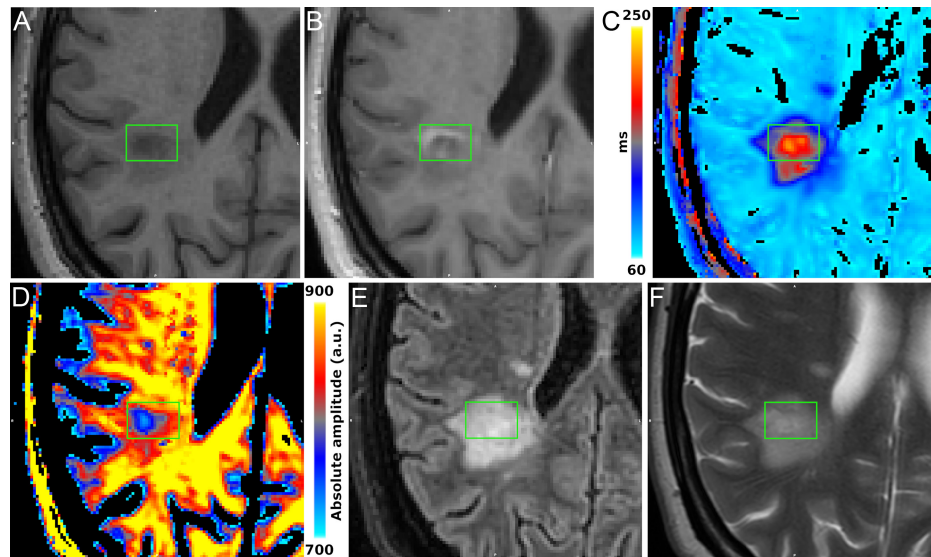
From top to bottom: T1-weighted images (pre- and post- contrast enhancement), maps of the intra-extracellular water component (IEwT2 map on the left and the corresponding amplitude on the right), T1-weighted images (FLAIR on the left and T2-image on the right). The green rectangular contour identifies the same region on all the different images/maps. IEwT2, T2 mapping of the intra/extra-cellular water.
